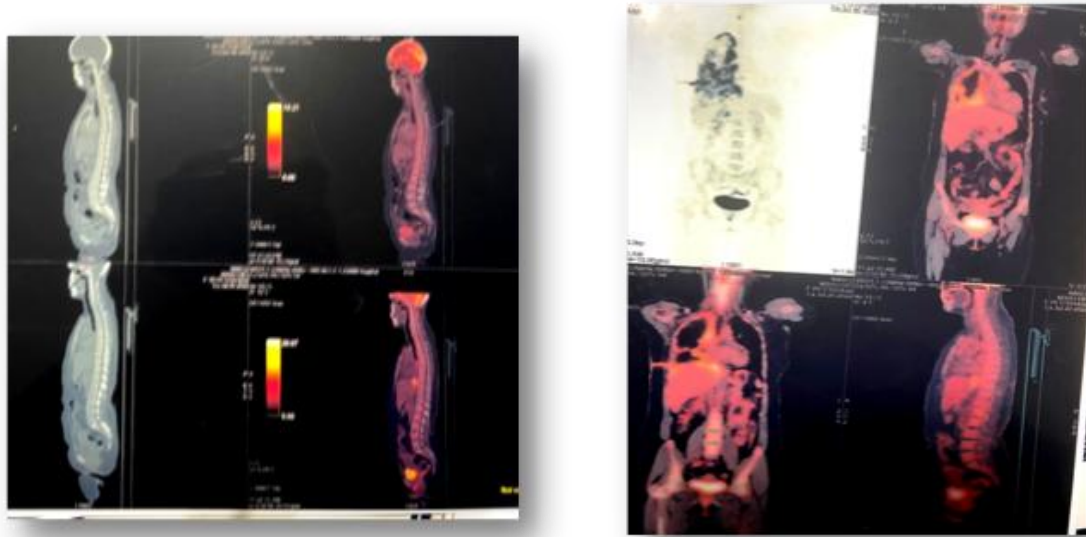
and b showing PET CT Scan image after 7cycles of dual blockade chemotherapy with Trastuzumab and Pembrolizumab, showing complete resolution of previous metabolically active lesions
